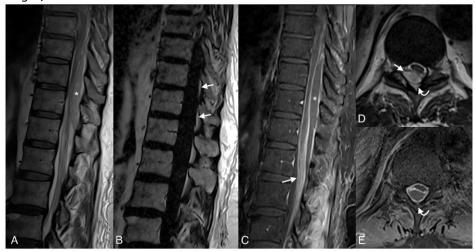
A 68-year-old patient with weakness in the context of CNS listeriosis. MRI demonstrates a high T2WI signal collection (asterisk in A) in the subdural space of the thoracolumbar region (note the preserved high T1WI signal of the fat pad in this region [arrows in B]) associated with ring enhancement on postcontrast T1WI (asterisk in C). There is also diffuse leptomeningeal enhancement of the cauda equina (arrow in C). Axial T2 (D) and postcontrast T1WI (E) confirm the location of the collection (arrow
